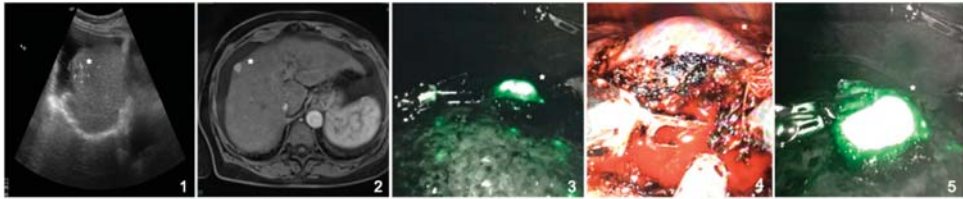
Pre- and intraoperative imaging of a 64-year-old female patient suffering from a hepatocellular carcinoma in liver cirrhosis (CHILD A). Indocyanine green accumulation in the hepatocellular carcinoma is clearly visible and shows full fluorescence (*). (1,2) Preoperative ultrasound and MRI-scan showing a hepatocellular carcinoma in segment VIII; (3) intraoperative, near infrared Firefly imaging showing indocyanine green accumulation in the tumor and the cirrhotic liver; (4) naive intraoperative image of the tumor; (5) intraoperative, near infrared Firefly imaging of the resected tumor.
